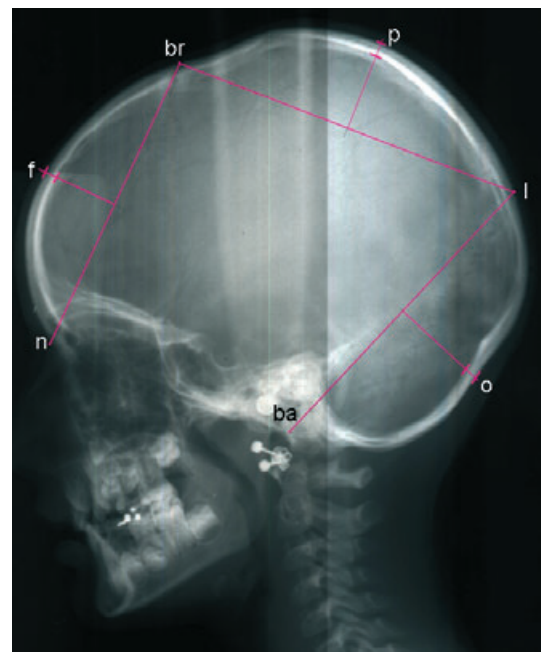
Profile radiograph of a 7-year-old girl with UCLP. On the radiograph is marked the location of the cephalometric fix points and lines necessary for measuring skull thickness: Basion (ba): the most posterior-inferior point on the clivus. Bregma (br): the intersection between the sagittal and coronal sutures on the surface of the cranial vault. Frontale (f): the point on the surface of the frontal bone determined by a perpendicular to the nasion-bregma line and passing through its midpoint. Lambda (l): the intersection between the lambdoid and sagittal sutures on the surfaces of the cranial vault. Nasion (n): the most anterior point on the fronto-nasal suture. Reference points according to Björk (28). The thickness of the frontal, parietal, and occipital bones were defined as the distances from the points where the perpendicular bisectors of the cords nasion-bregma, bregma-lambda, and lambda-basion intersected the inner and outer contours of the respective bones (the points f, p and o). This definition is according to Axelsson et al. (21).
